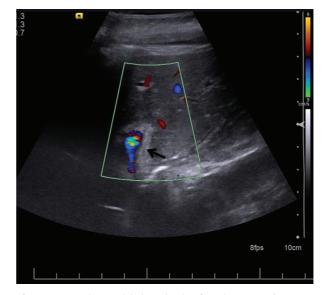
Hepatic Arterial Thrombosis After Liver Transplant Hepatic artery located medial to the portal vein is seen hypoechoic (black arrow) in color Doppler imaging, showing there is no flow in it because of thrombosis.
